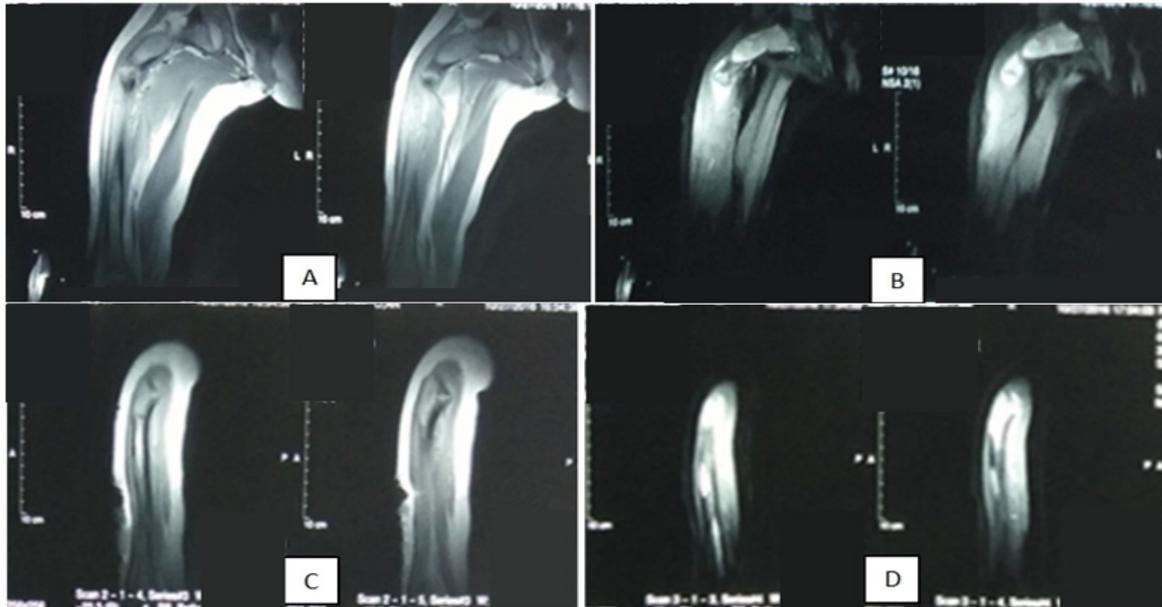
The MRI of one-third proximal right femur in FD with pathological fracture. T1W1 (A) and T2W1 (B) of MRI coronal section, T1W1 (C) and T2W1 (D) of MRI sagittal section.
